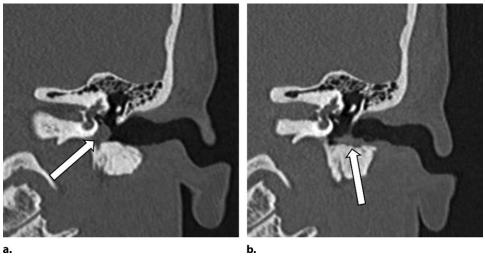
Transcanal approach for resection of tympanic paraganglioma. (a) Preoperative coronal CT image shows a nodular lesion adjacent to the cochlear promontory (arrow). (b) Postoperative coronal CT mage shows soft-tissue thickening and osseous irregularity of the inferior wall of the EAC (arrow) related to the transcanal approach.
